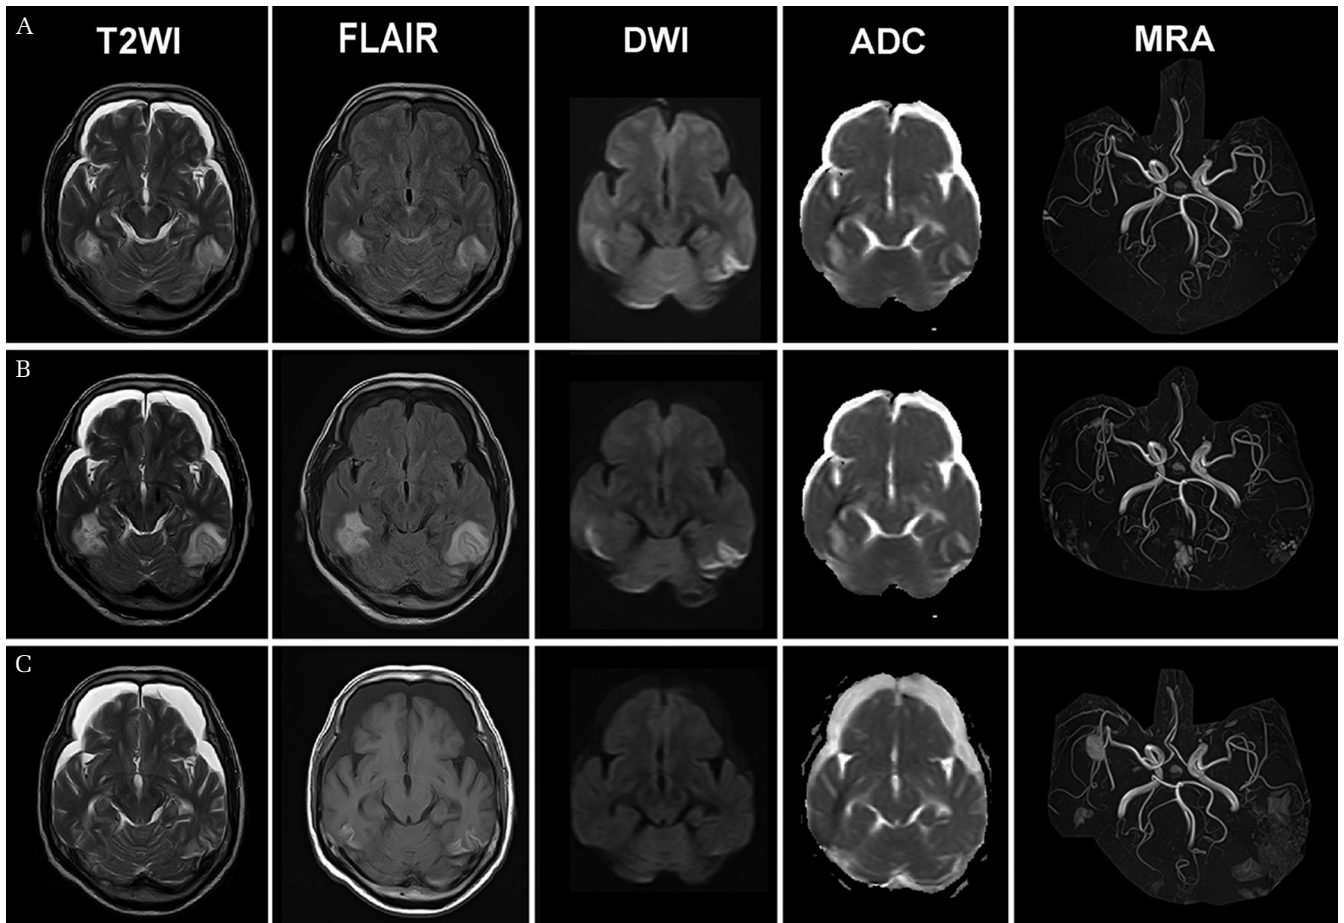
(A) On admission. Brain MR imaging shows hyperintense on T2WI, FLAIR, DWI, and ADC images; (B) Twelve days after admission. Brain MR imaging shows increased signals of hyperintense regions on T2WI, FLAIR, DWI, and ADC images; (C) Twenty-four days after admission. Complete disappearance of the T2WI, FLAIR, DWI, and ADC hyperintense regions is consistent with the characteristic images of PRES.
